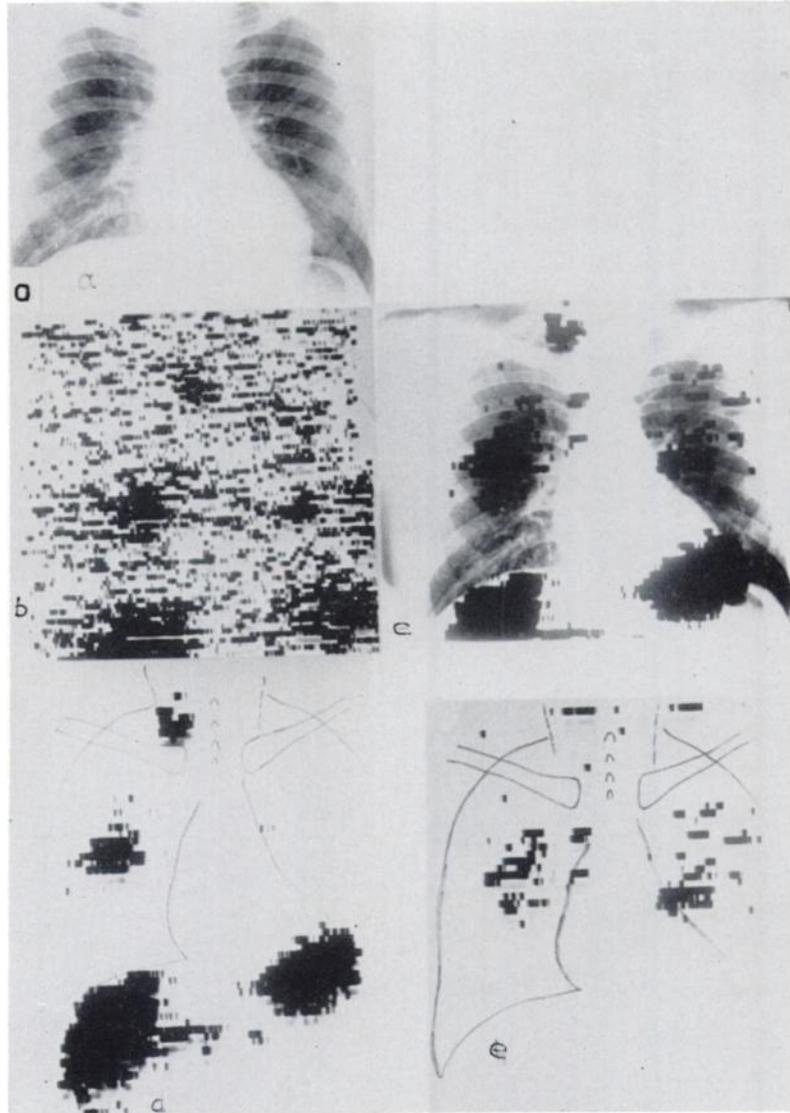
Lung metastases of follicular adenocarcinoma of the thyroid, a. Chest x-ray showing no metastases, b. Chest scan with ^{131}I , c. Superposition of chest and back scan with ^{125}I and x-ray picture, d. Anterior scan with ^{125}I , e. Posterior scan with ^{125}I . (This scan is shown from the anterior aspect to permit easy comparison with scan d). Note concentration of radioiodine in stomach and liver in scan d.
